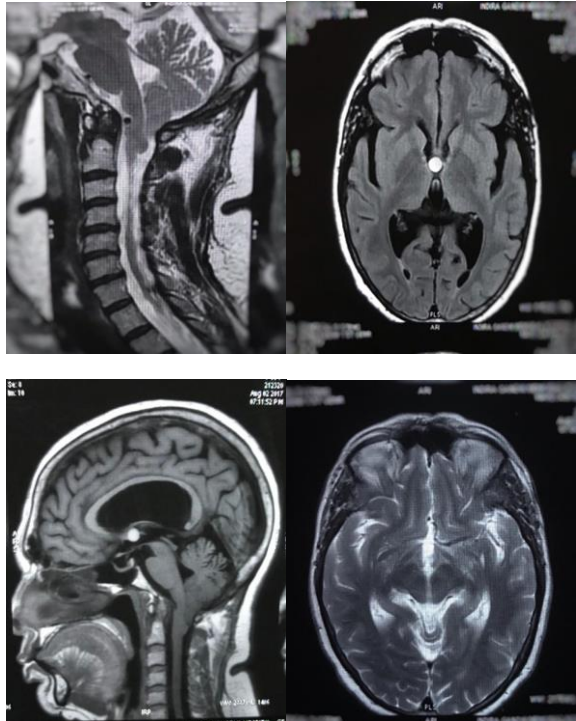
(a): T2 weighted MRI Sagittal: tonsillar herniation and syringomyelia, (b): T1 weight MRI Axial: colloid cyst in the 3rd ventricle, (c): T1 weight MRI Sagittal: colloid cyst in the 3rd ventricle, (d): T2 weighted MRI Axial: Hydrocephalus. Visible temporal horns and sylvian fissure
